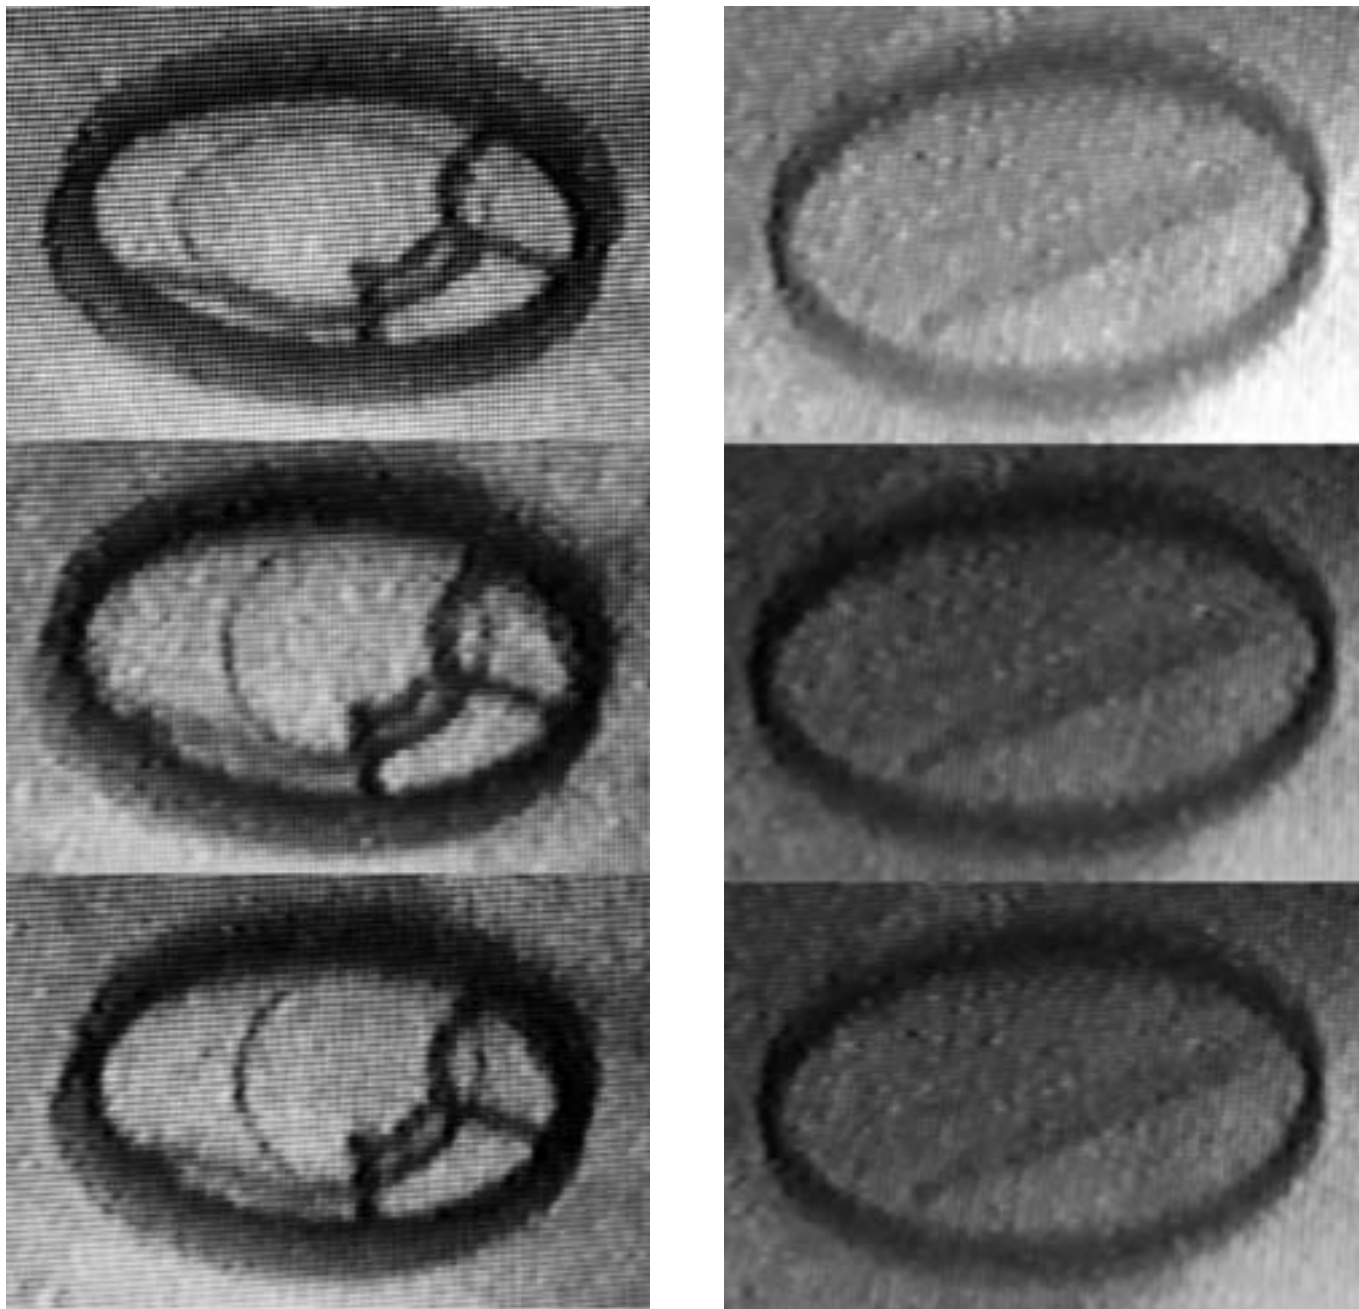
Representative images from the fluoroscopic valve evaluation. Still images were taken from the recorded X-radiograph video. The images show three consecutive photographs within a time frame of 1 s. A) Three consecutive images of a normal functioning monoleaflet valve. B) Three consecutive images of a bileaflet valve with obstruction of one cusp; the blocked cusp is always in the same position.
